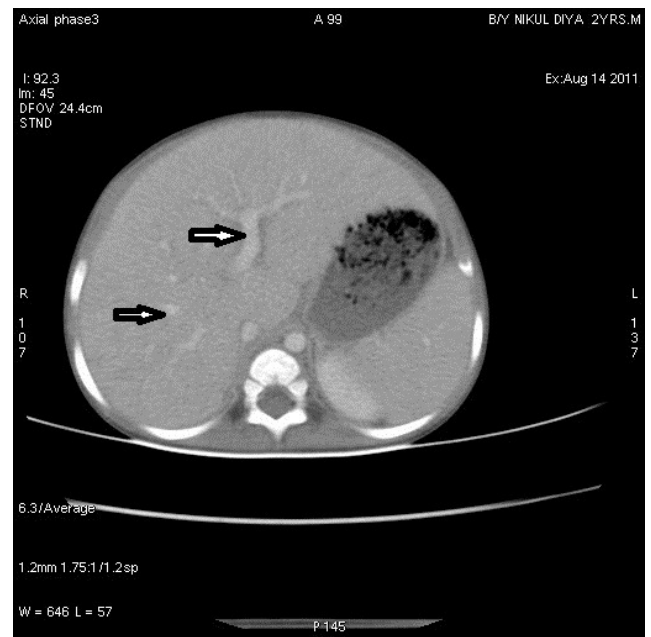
CT scan image of patient showing prominent periportal cuffing
